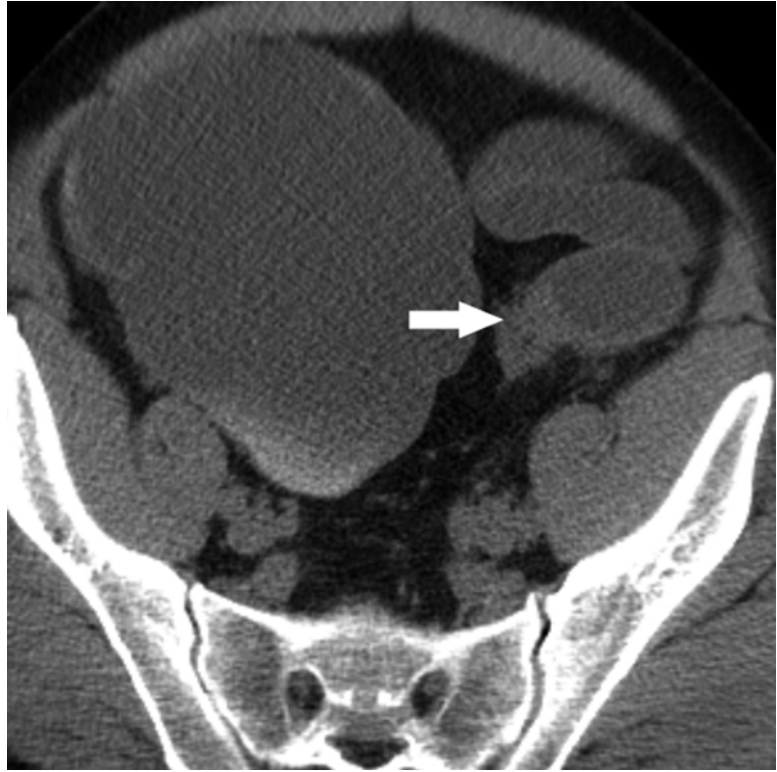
Malignant sigmoid colon obstruction. CT with arrow indicating abrupt transition from dilated to decompressed sigmoid colon in the setting of cancer involving the proximal sigmoid colon
